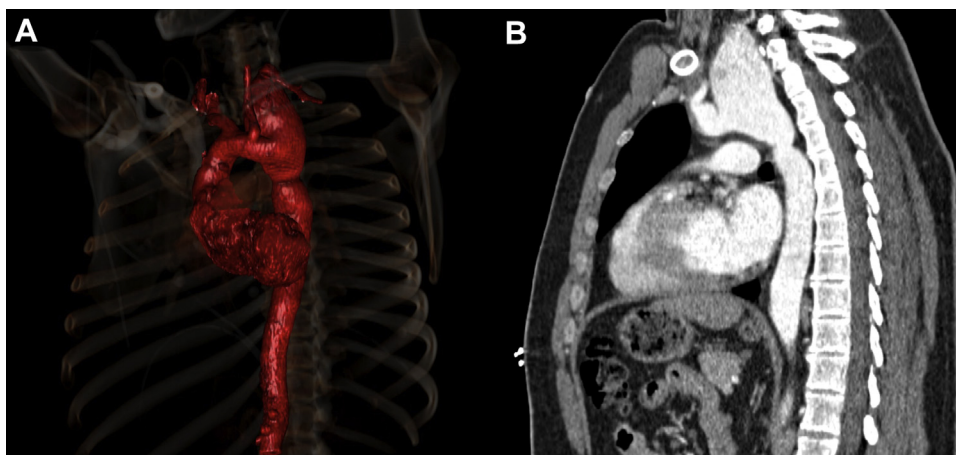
Three-dimensional computed tomography reconstruction (A) and standard computed tomography angiography (B) of the aorta and supra-aortic trunks demonstrating a patulous 8-cm left subclavian aneurysm causing lack of outer arch curvature, with distal arch and transverse arch severe angulation and distal pseudo-coarctation. These features made traditional transfemoral catheterization and stiff wire placement in the ascending aorta difficult.
